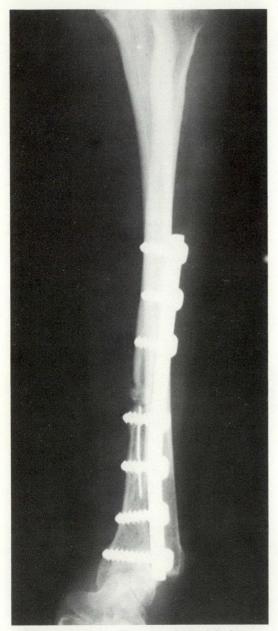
Lateral radiograph of the left forearm 18 months after operation showing replacement of the distal radius by fibular autograft.
